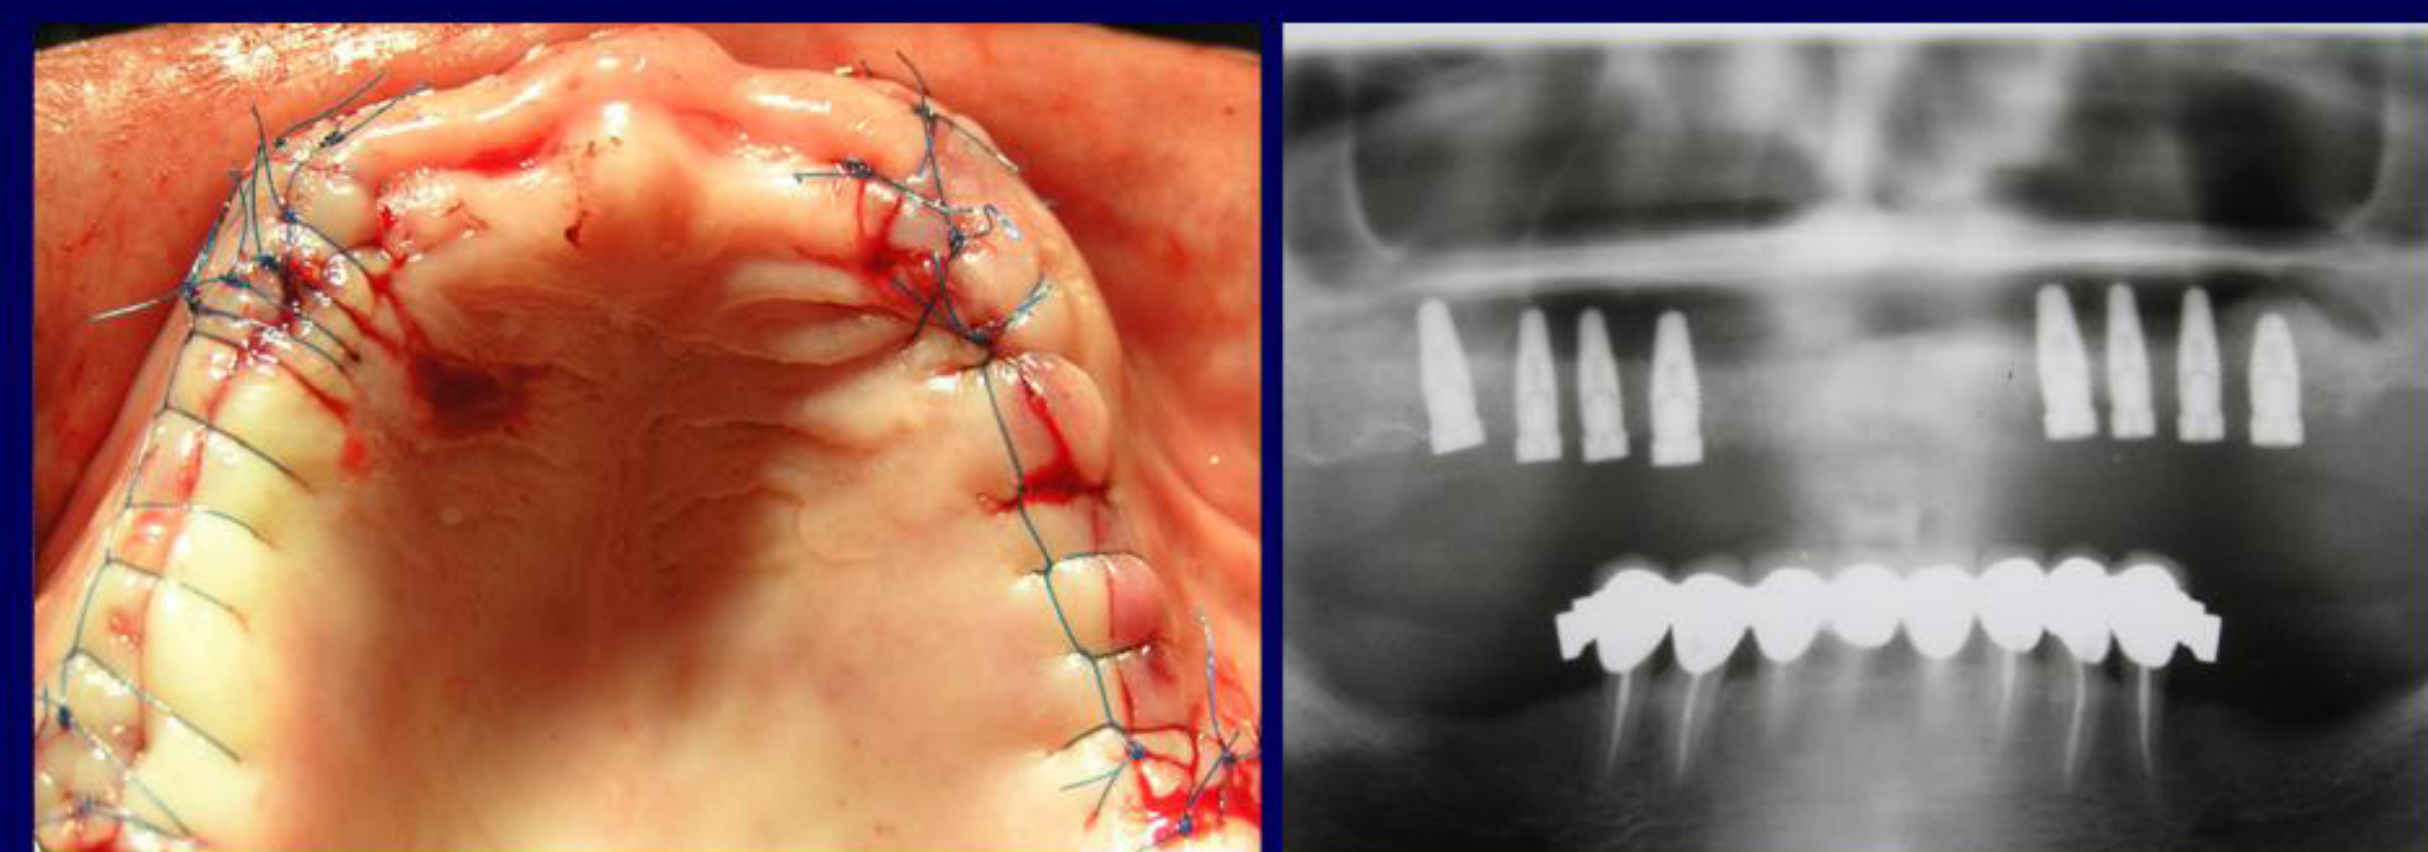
Submucosal healing and post-operative radiograph.
